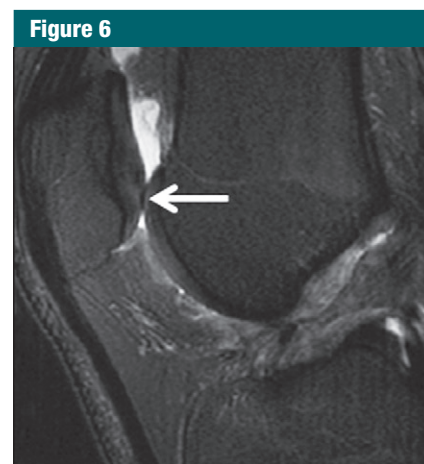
Images in 37-year-old man with arthroscopically normal articular cartilage on patella (classified as MR grade 1A cartilage lesion). (a) Sagittal fat-suppressed T2-weighted fast spin-echo image shows normal-appearing articular cartilage on patella (arrow). (b) Corresponding sagittal T2 map shows area of increased T2 relaxation time on patella (arrow).
